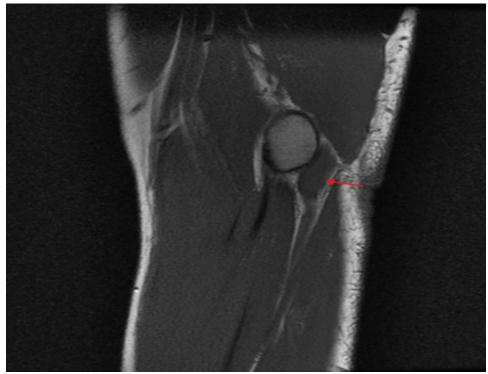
The MRI T1 FSE (Fast Spin Echo) sagittal view shows an enlarged and thickened ulnar nerve within the cubital tunnel.
